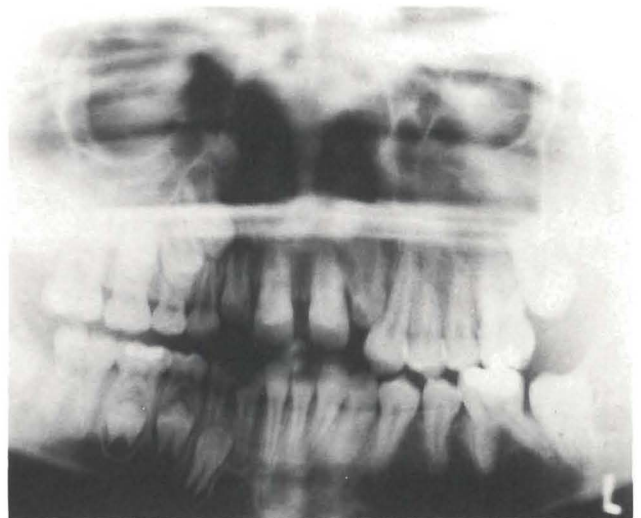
Panoramic radiograph at age 7.7 years, demonstrating age-consistent dental development and eruption pattern on the right side, compared to advanced development on the left side.
